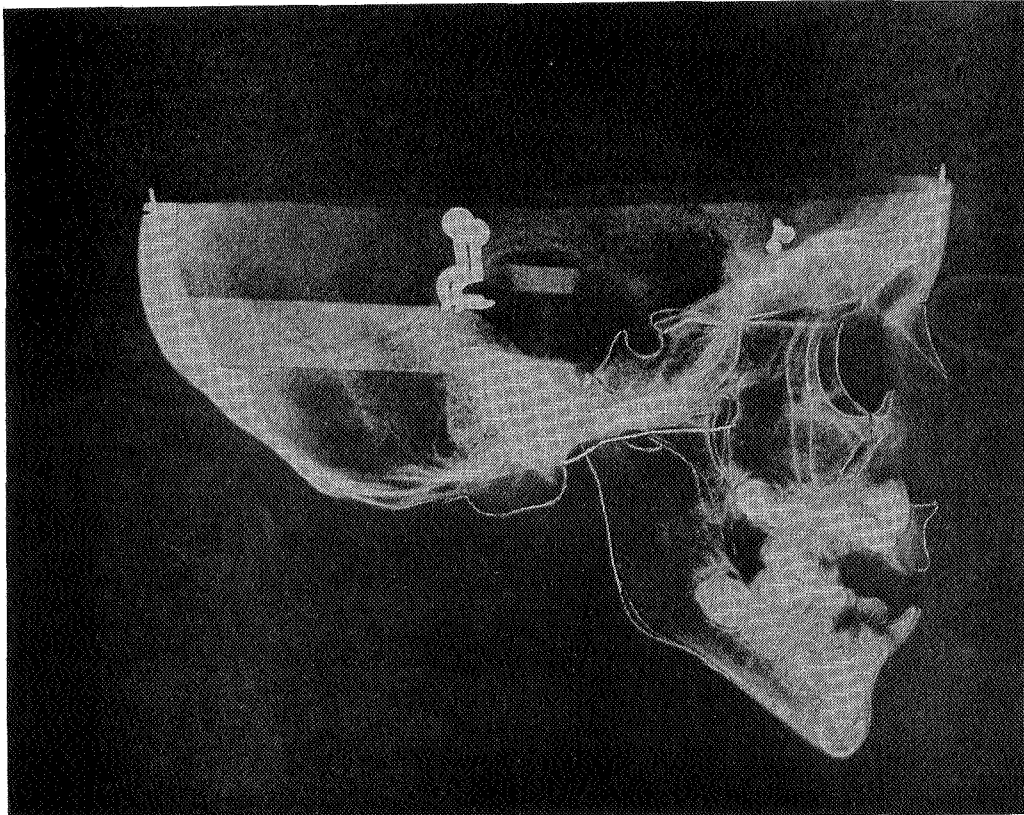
Lateral cephalometric radiograph of 9 year old skull (note wires on cribriform plate below internal wall of frontal bone).
